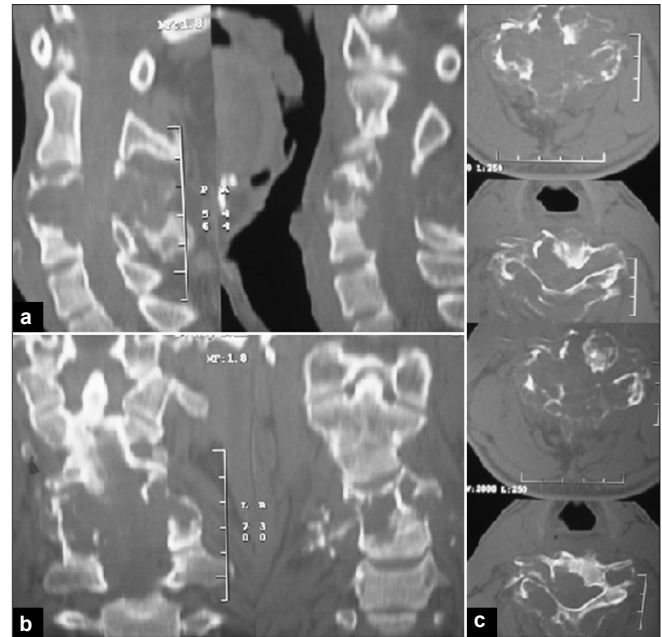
(a) Reconstructed sagittal cervical spine CT scan showing destruction of C3/C4. (b) Sagittal T2W MRI showing involvement of C3/C4 anteriorly and posteriorly with cord compression. (c) Axial MRI T2W images showing expansile bony lesion with multiple blood filled cavities involving vertebral body, lateral masses and posterior elements. Arrow showing engulfed and anteriorly displaced vertebral arteries (Right>left)
